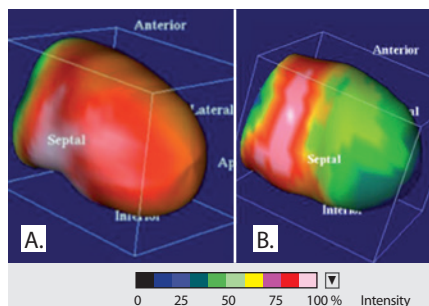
A,B: PET/CT images of free fatty acid analogue ^{18}F -fluoro-cyclopropyl hexadecanoic acid (^{18}F -CPHA). A Normal myocardium with homogeneous distribution of ^{18}F -CPHA associated with normal free fatty acid metabolism. B Abnormal myocardium with areas of decreased fatty acid metabolism from metabolic shift associated with anaerobic metabolism and injury
